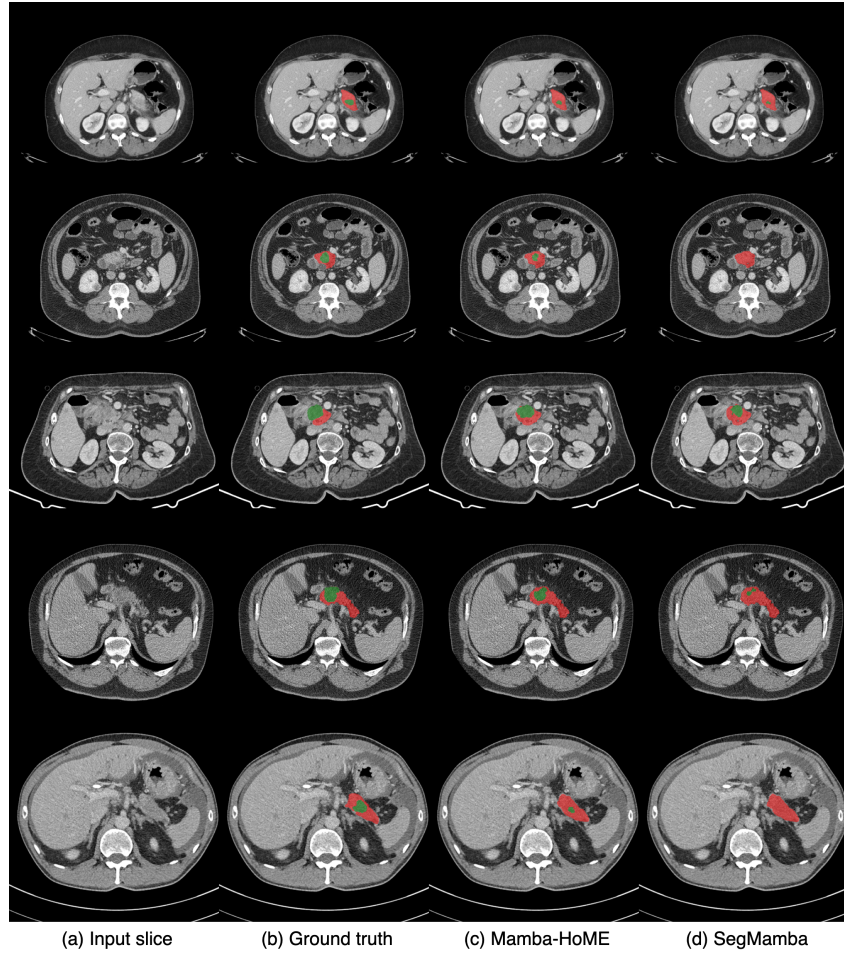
Qualitative comparison of Mamba-HoME and SegMamba on abdominal CT scans from PANORAMA test set. The images highlight the impact of the HoME layer added to the baseline SegMamba model, with green (PDAC) and red (pancreas) annotations indicating segmentation differences. Mamba-HoME demonstrates robustness and improved accuracy in detecting both small and large anatomical structures, like tumors, compared to SegMamba alone. Please note that we show Mamba-HoME results trained from scratch.
